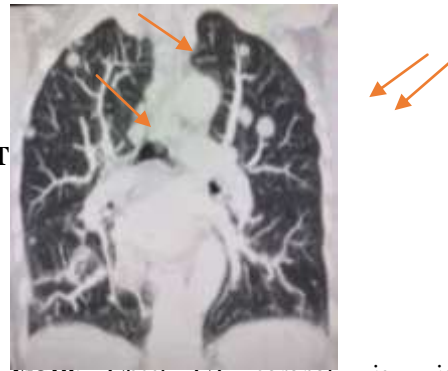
Chest CT coronal view in pulmonary window revealing bilateral parenchymal and subpleural nodules of secondary appearance.
